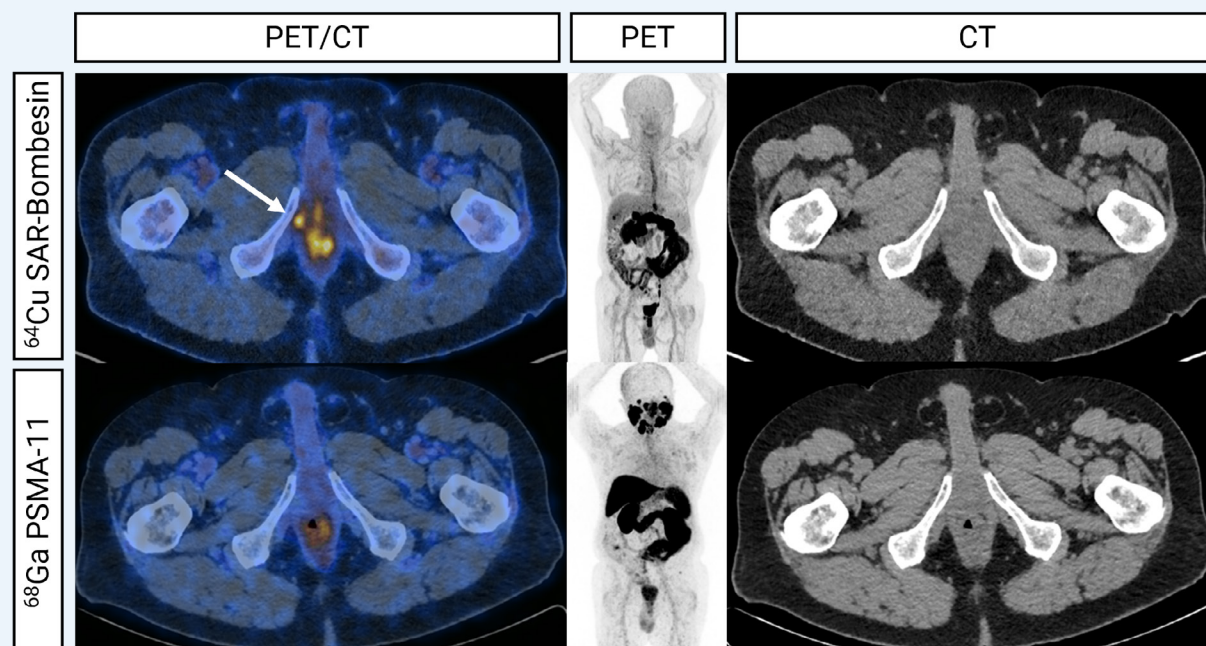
Fused, MIP and CT (left to right) images from ^{64}Cu -SAR-Bombesin (top) and ^{68}Ga -PSMA-11 (bottom) PET of a patient demonstrating uptake at the right urethral anastomosis on ^{64}Cu -SAR-Bombesin alone (arrow). This patient was managed with local radiotherapy with improvement in PSA post-treatment.
